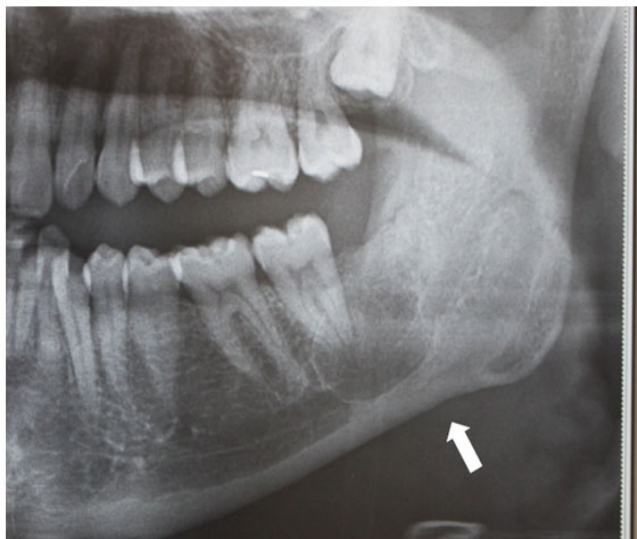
Bony union seen, 6 months later on panoramic radiograph (arrow).
